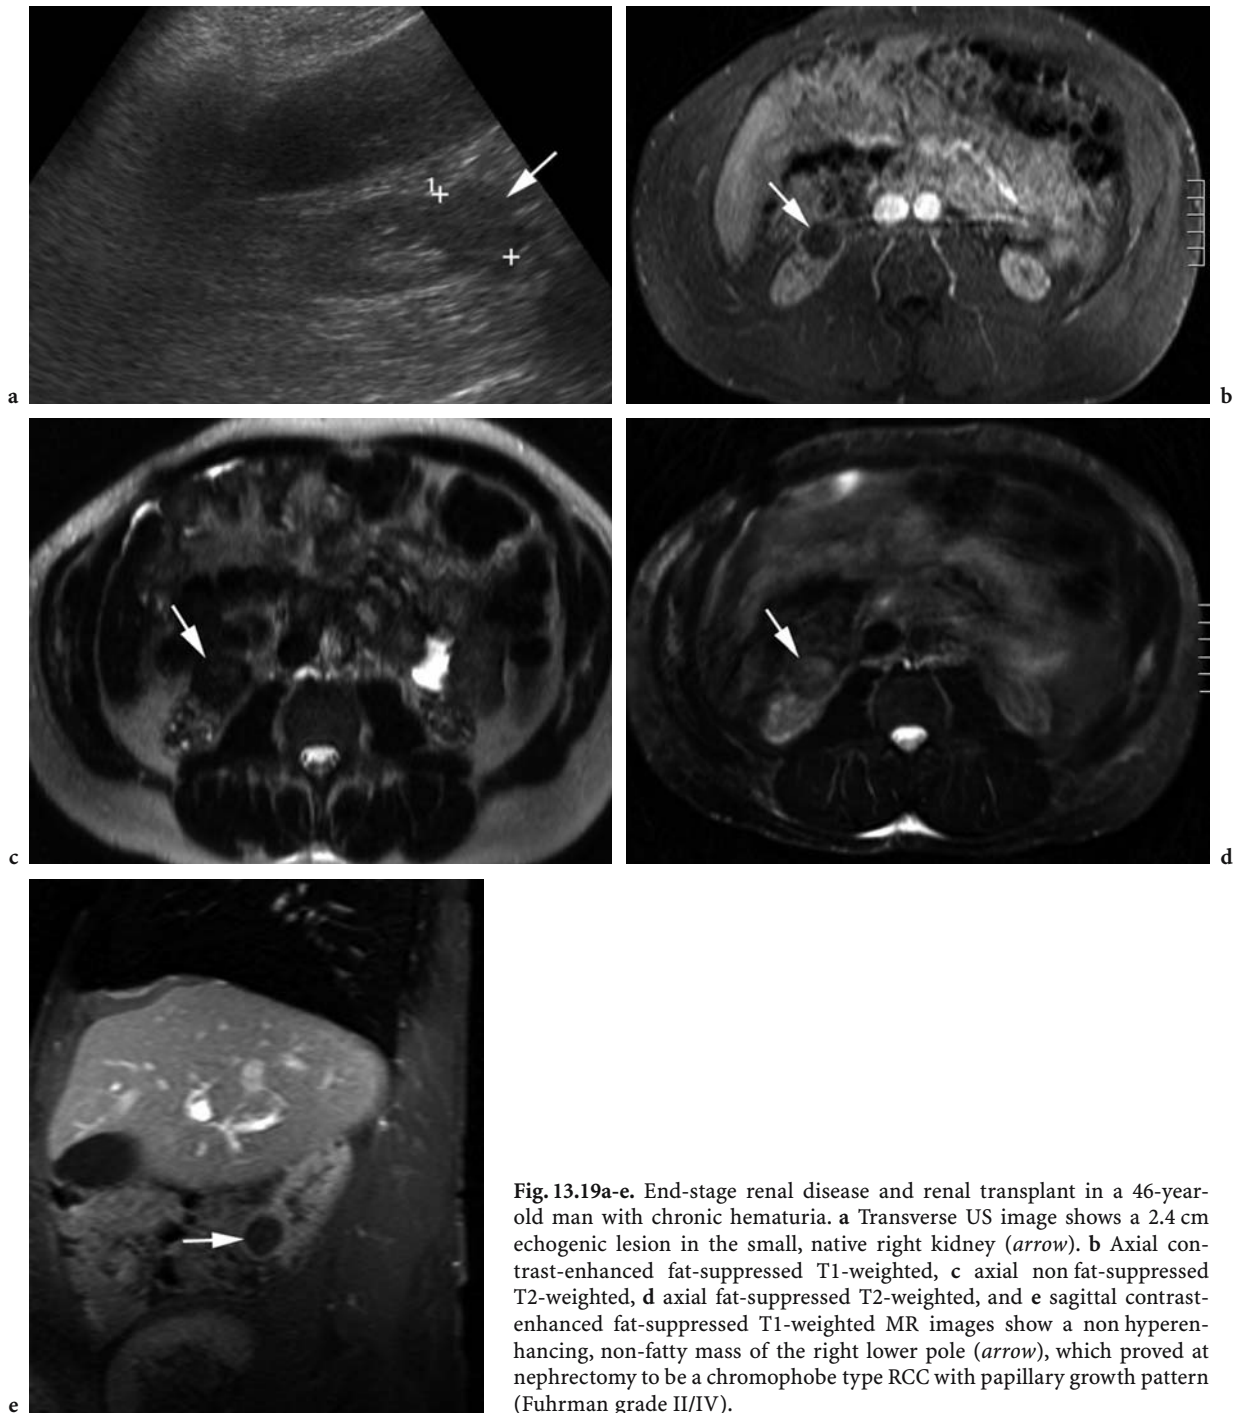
End-stage renal disease and renal transplant in a 46-year-old man with chronic hematuria. a Transverse US image shows a 2.4 cm echogenic lesion in the small, native right kidney (*arrow*). b Axial contrast-enhanced fat-suppressed T1-weighted, c axial non fat-suppressed T2-weighted, d axial fat-suppressed T2-weighted, and e sagittal contrast-enhanced fat-suppressed T1-weighted MR images show a non hyperenhancing, non-fatty mass of the right lower pole (*arrow*), which proved at nephrectomy to be a chromophobe type RCC with papillary growth pattern (Fuhrman grade II/IV).
